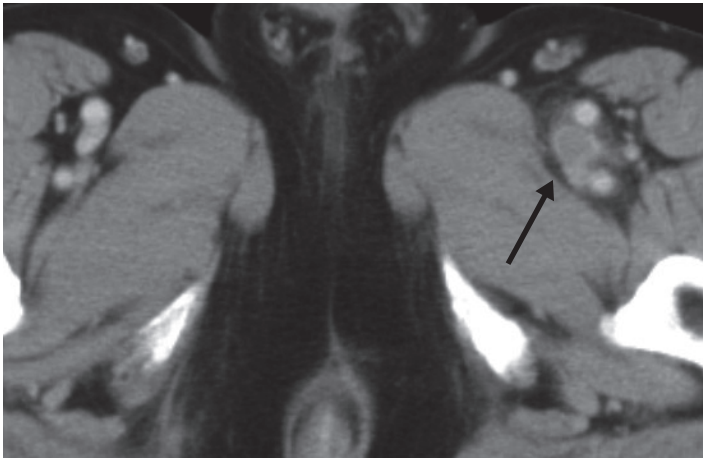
A 65 year-female with acute thrombophlebitis. CT image showed dilatation of femoral vein with wall enhancement and dirty fat around the vein. CT attenuation of thrombus (arrow) was 78 HU.
